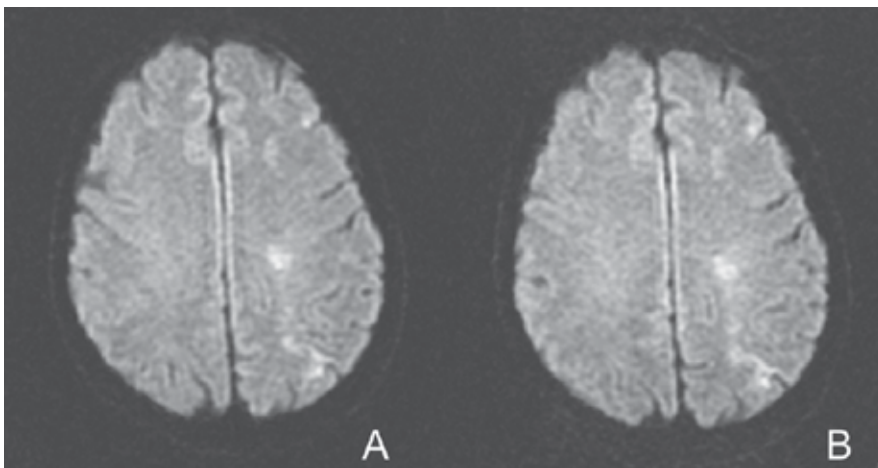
Patient number 7, male, 60 years old, underwent angioplasty of the left carotid artery. Restriction foci in DWI in the MRI scan before CAS (A). Manifestation found in 11.11% of patients. No NF were observed after CAS (B)
